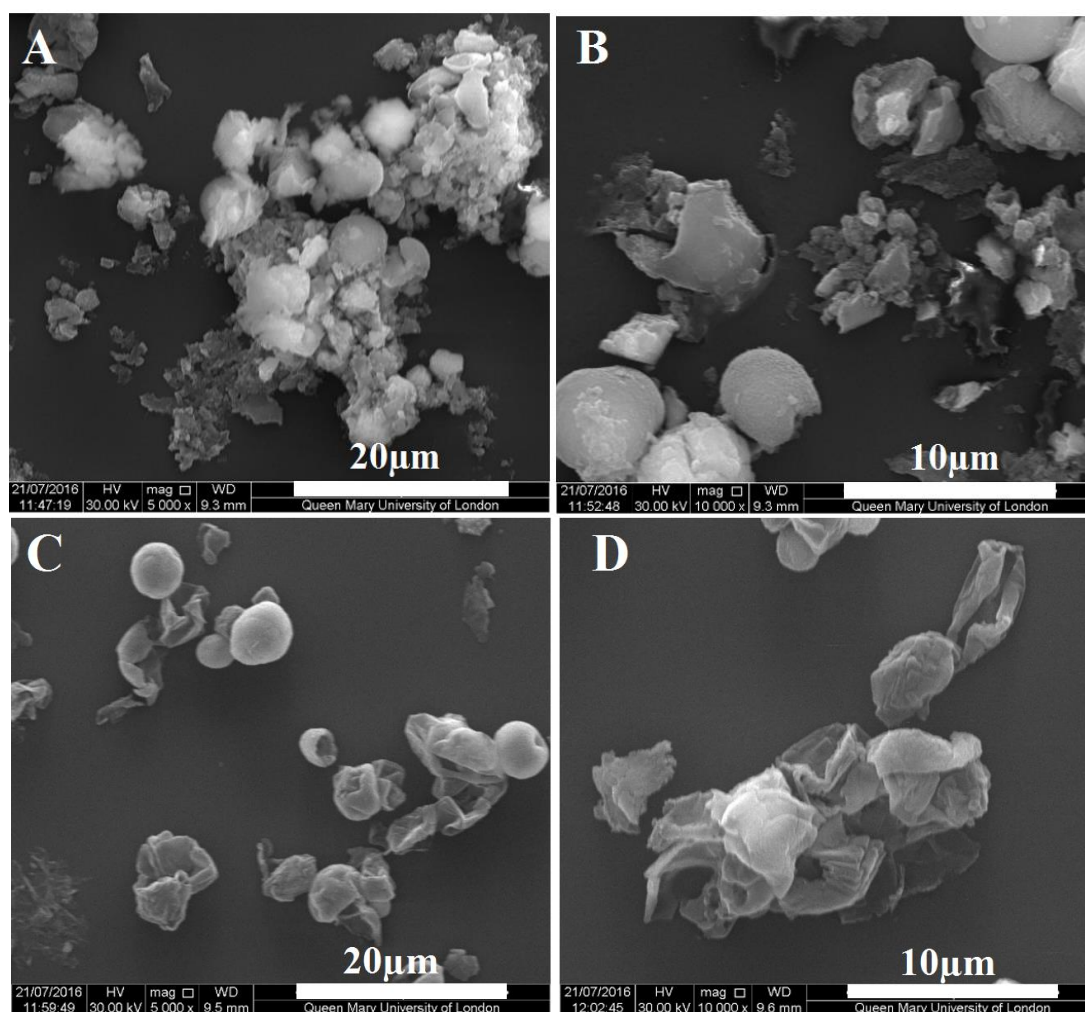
SEM images of $\text{CaCO}_3/(\text{PAH/PSS})_6/\text{SiO}_2$ particles ultrasonicated for 6s before (A, B) and after (C, D) EDTA treatment.
